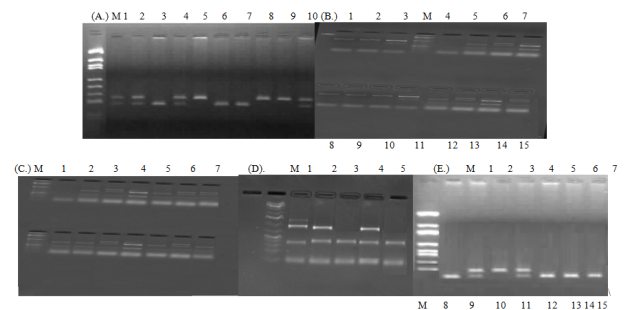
Representative results of *ESR1* SNPs restriction digestion (A.) rs138724640 restriction fragments (bp); Genotype: TT Lanes 5, 8, 9. TC lanes: 1, 2, 4, 10. CC lanes 3, 6, 7. (B.) rs2234693 restriction fragments (bp); Genotype: TT Lanes 1, 2, 3, 8, 9, 10. TC lanes 5, 6, 7, 14. CC lanes 11, 12, 15. (C.) rs9340799 restriction fragments (bp); Genotype: AA Lanes 6, 8, 9. AG lanes 4, 10, 11. GG lanes 2, 3, 5, 6, 7, 13, 14, 15. (D.) rs373404617 restriction fragments (bp); Genotype: GG Lanes 3, 5. GA lanes 2, 4. AA lanes 1. (E.) rs2077647 restriction fragments (bp); Genotype: CC Lanes 3. CT lanes 2, 4. TT lanes 1, 5, 6, 7. (Agarose conc.-1.5%, voltage-100 V, time-30 min).
